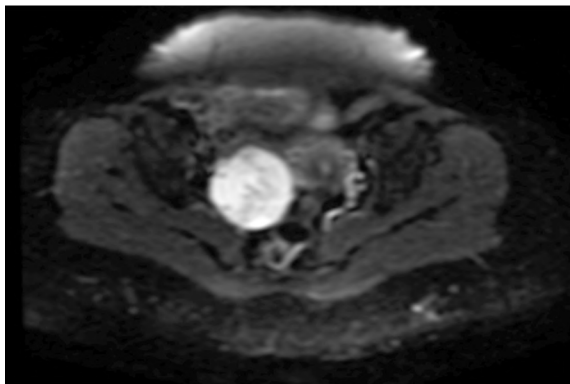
DWI diffusion restriction of the solid component.
